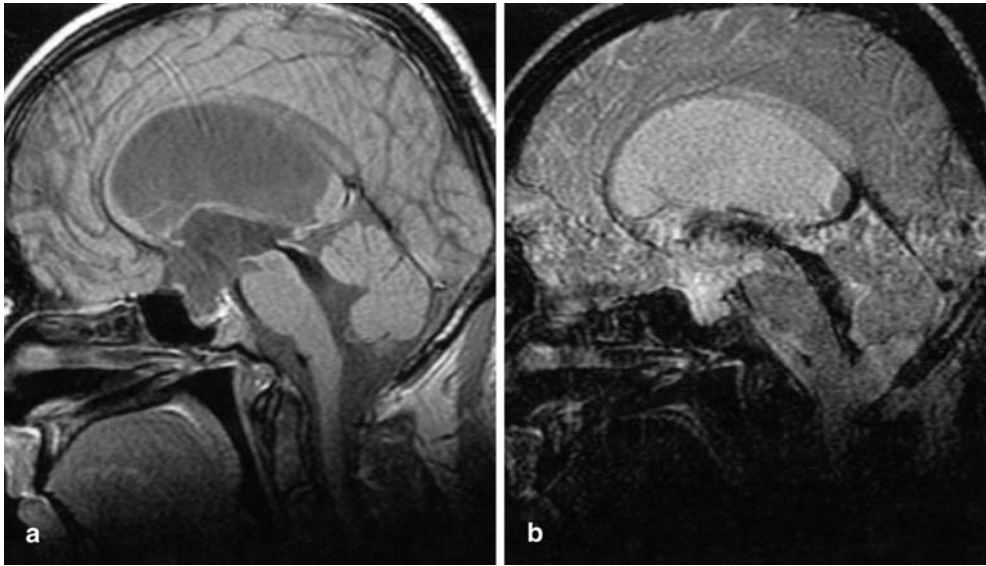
Aqueduct: a standard dual echo sequence without flow compensation can be used to demonstrate or rule out intraventricular CSF obstructions. a The proton-density weighted image of this case of communicating hydrocephalus demonstrates the anatomy with widening of aqueduct. b The T2-weighted image shows a marked “flow void” in the aqueduct, the third and the fourth ventricle. This
